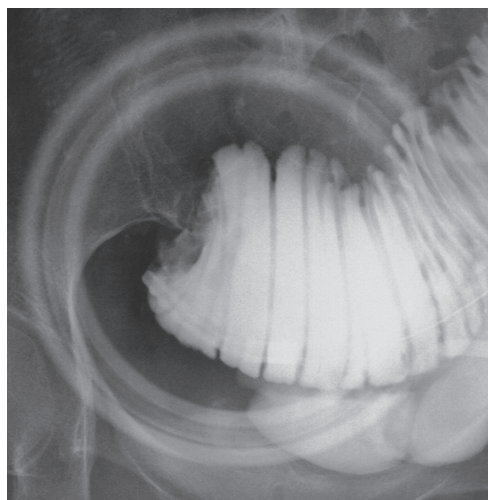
Ileus tube contrast radiography. Obstructive part was observed in the jejunum at about 50 cm from the Treitz ligament.
